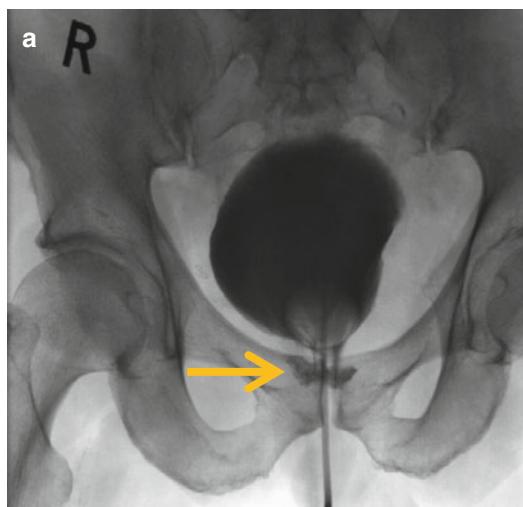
Anastomotic leak following a radical prostatectomy. (a) Fluoroscopic cystogram demonstrates an extraperitoneal urine leak (arrow) at the level of the anastomosis. (b) Axial images from the CT cystogram
